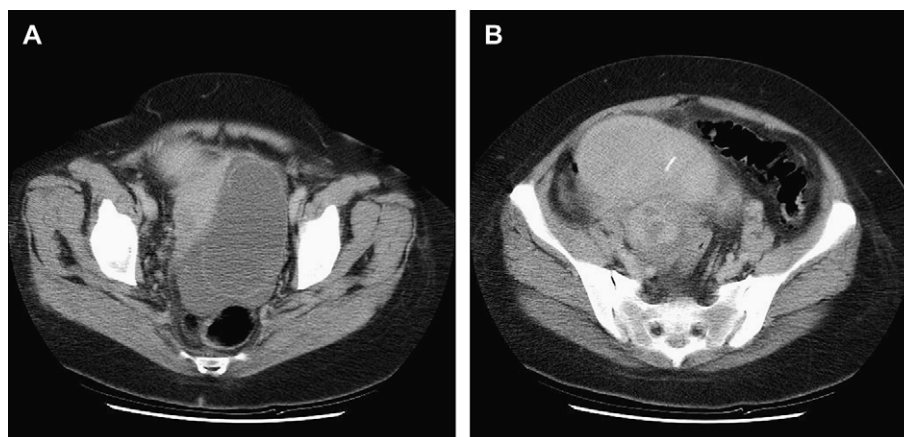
CT scans of a 52 year old lady who underwent total hysterectomy and bilateral salpingo-oophorectomy for the septated left ovarian cystic mass (A) and right sided solid/cystic mass (B) reported as most in keeping with ovarian carcinoma. A radio-opaque IUCD is visible in the uterus anteriorly.
